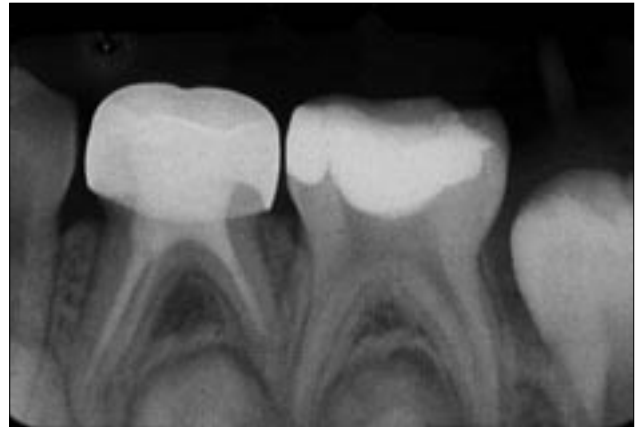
Immediate postoperative radiograph. All canals were judged to be underfilled.
